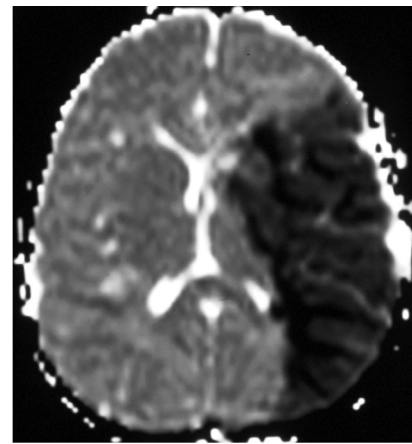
DWI & ADC show diffusion bright and corresponding low apparent diffusion co-efficient (ADC) value suggestive of acute infarct in the left middle cerebral artery territory
